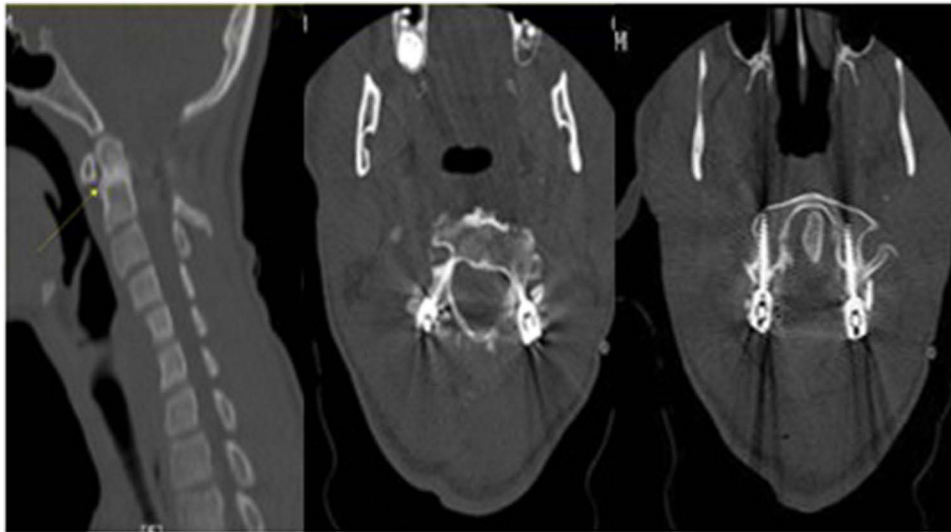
Postoperative CT scan of the cervical spine showed atlantoaxial PSF with complete reduction and fusion with normal alignment of AAJ and fractured odontoid (white arrow).
